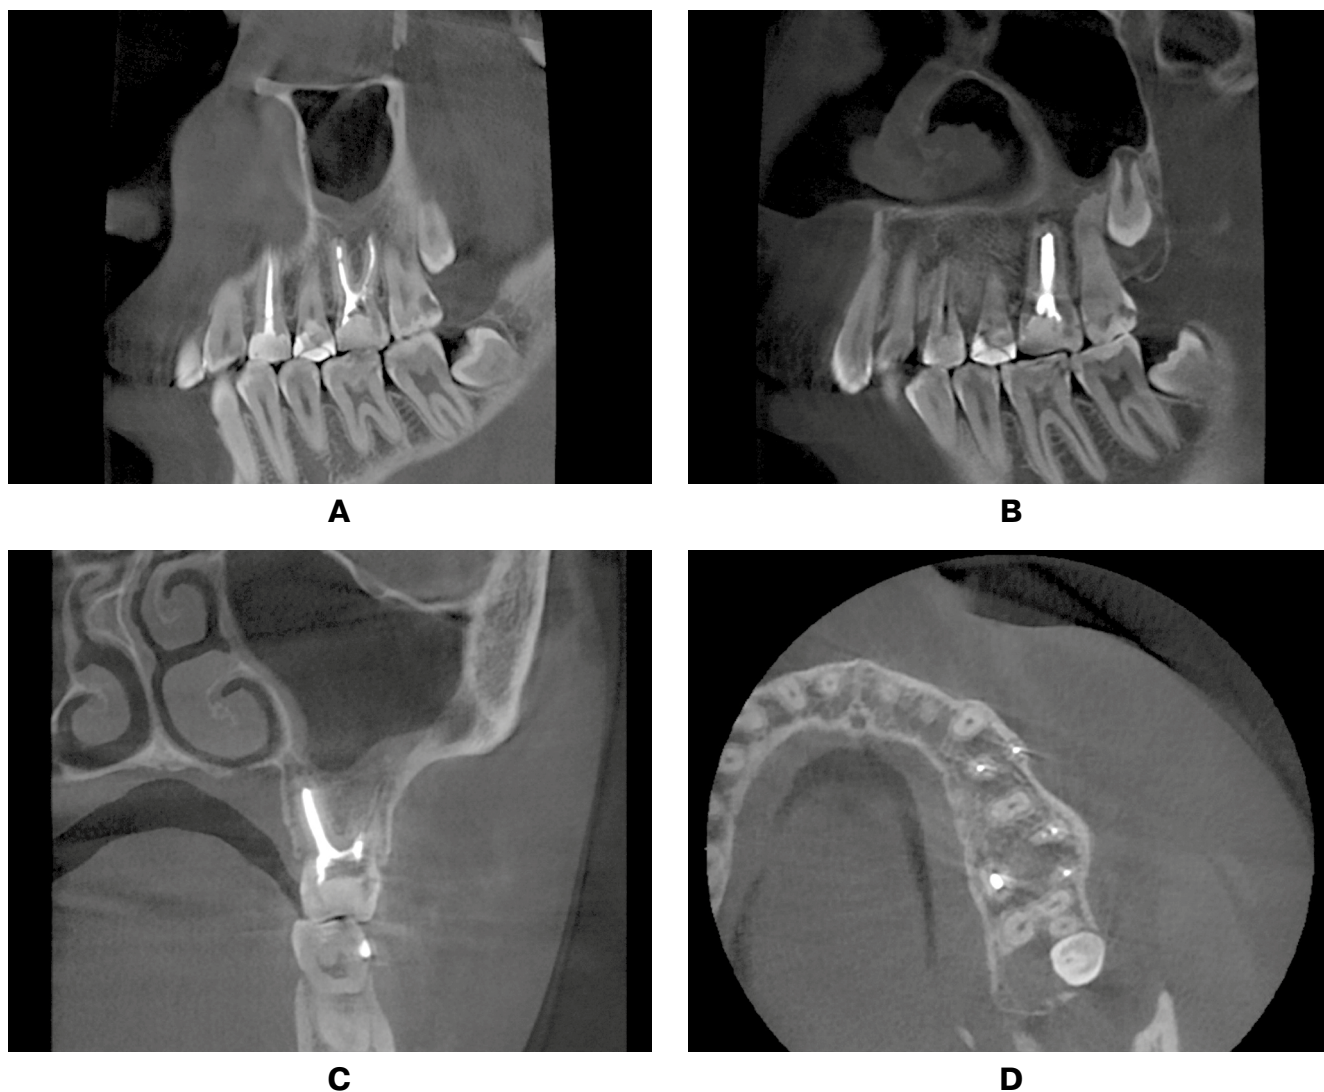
Dynamic observation after 3 months. CBCT of the tooth 2.6: A, B – sagittal section; C – coronal section; D – axial section
